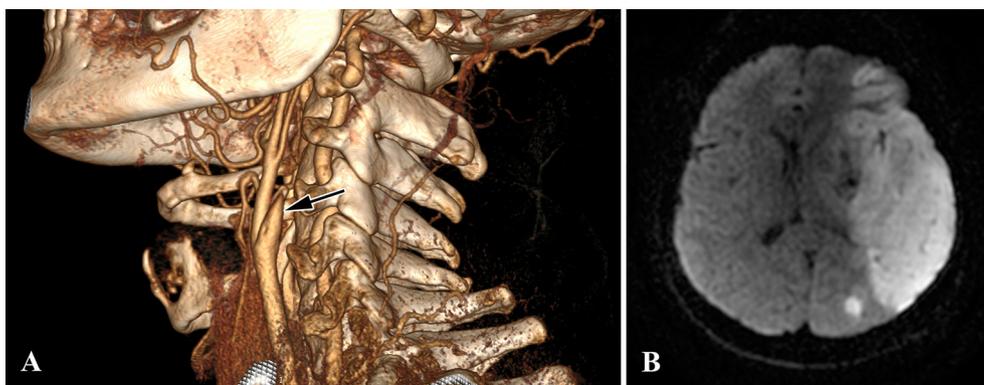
A flame sign (arrow) of a dissection and tapered occlusion of the left internal carotid artery on a 3D CTA image (A), and a large ischemic region in the territory of the middle cerebral artery on an axial DWI image (B).
